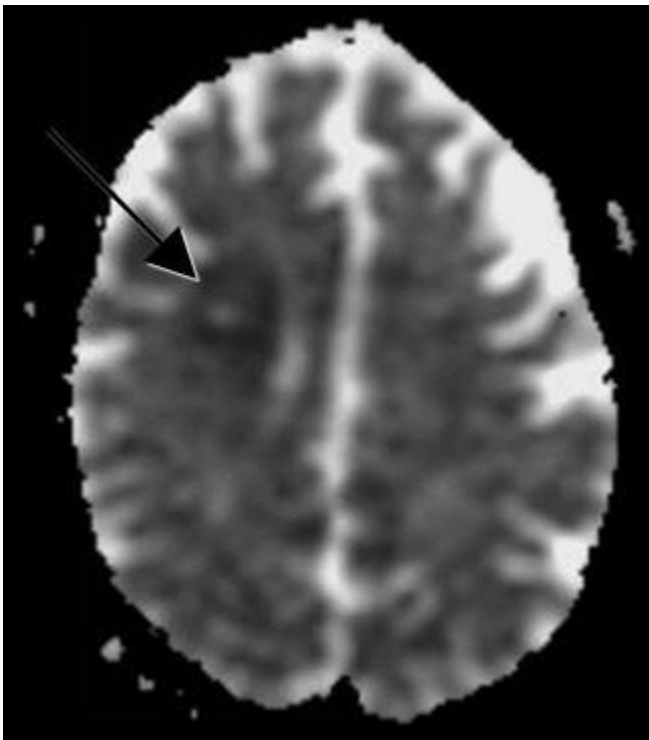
Brain MRI without contrast (ADC map): Showing infarct in the right centrum semiovale (arrow).
